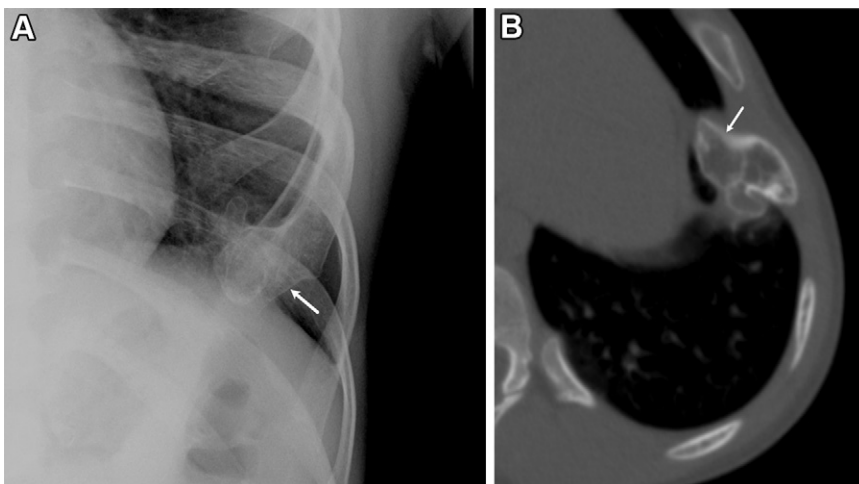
Osteochondroma in a 14-year-old boy with multiple hereditary exostoses. (A) Frontal chest radiograph shows an osseous ingrowth (arrow) at the anterior aspect of the left seventh rib. (B) Axial CT image of the chest shows an osseous protuberance with corticomedullary continuity (arrow).
